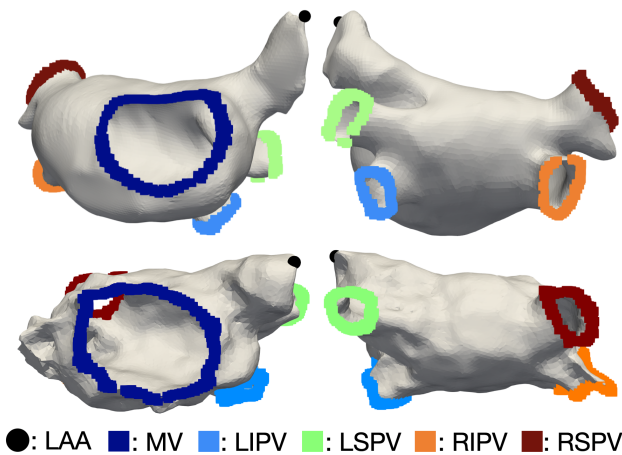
Output of the atrial openings annotation step (mitral valve and roof view of the labelled atrial orifices). Top row: example based on an MRI segmentation (patient 28). Bottom row: example based on an electroanatomical map (patient 28). LAA: left atrial appendage apex, MV: mitral valve, LIPV: left inferior pulmonary vein, LSPV: left superior pulmonary vein, RIPV: right inferior pulmonary vein, RSPV: right superior pulmonary vein.
